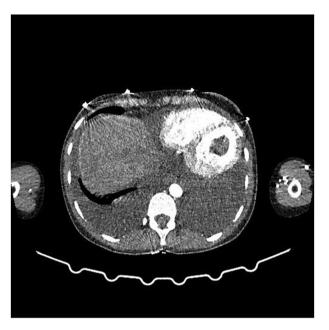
Thorax computed tomography reveals right-sided pleural effusion and filling defect compatible with thrombus in the left ventricle.
